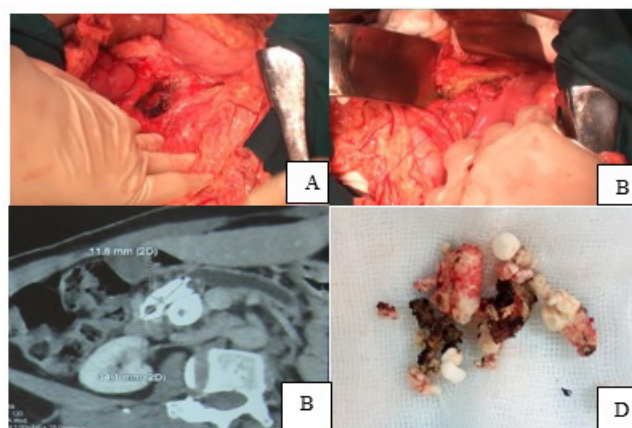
Several large stones in pancreatic head in abdomen pelvic CT scan. (A) Frey's procedure. (B) Longitudinal side-to-side pancreaticojejunojejunostomy. (C) Preoperative CT scan. (D) Pancreas Stone.
